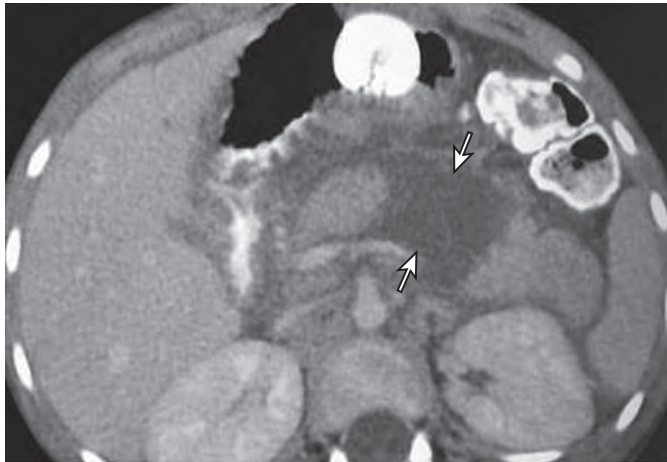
CT findings in pancreatic transection. CT scan of a pediatric patient, victim of child abuse, shows a large, well-demarcated lucent defect representing a pancreatic fracture with transection of the pancreas (arrows). (Courtesy Christine Menias, Mallinckrodt Institute of Radiology, St. Louis, Mo.)
